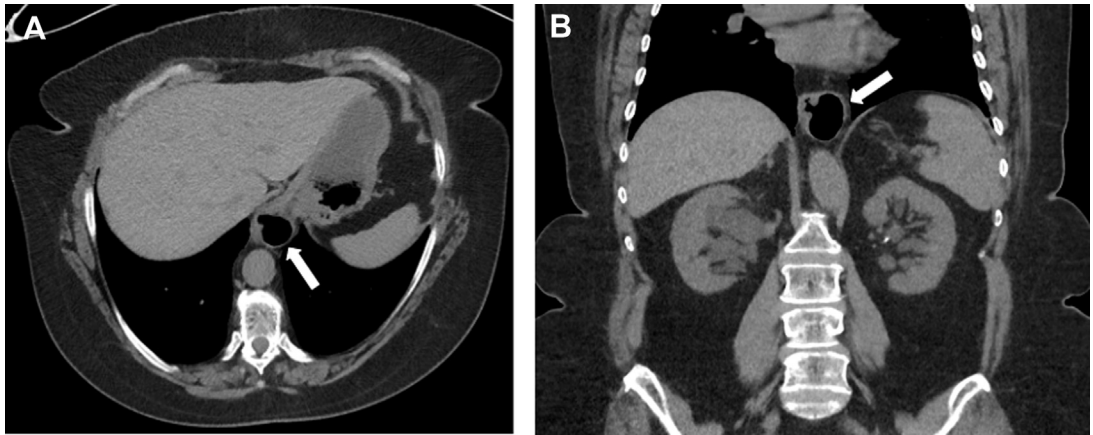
Epiphrenic esophageal diverticulum. A 57-year-old man with suspected renal/ureteral calculi. Axial (A) and coronal (B) images from CT performed without oral or intravenous contrast shows an epiphrenic pulsion diverticulum of the distal esophagus (arrows). Although the imaging appearance can be similar, the finding should not be misinterpreted as a hiatal hernia.
